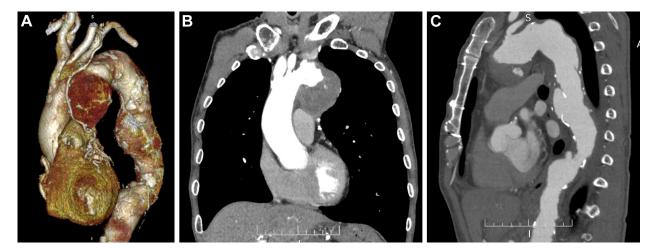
Preoperative computed tomographic angiography. (A) Three-dimensional reconstruction showing the saccular aneurysm of the aortic arch and internal thoracic artery graft adjacent to the aneurysm. (B)
